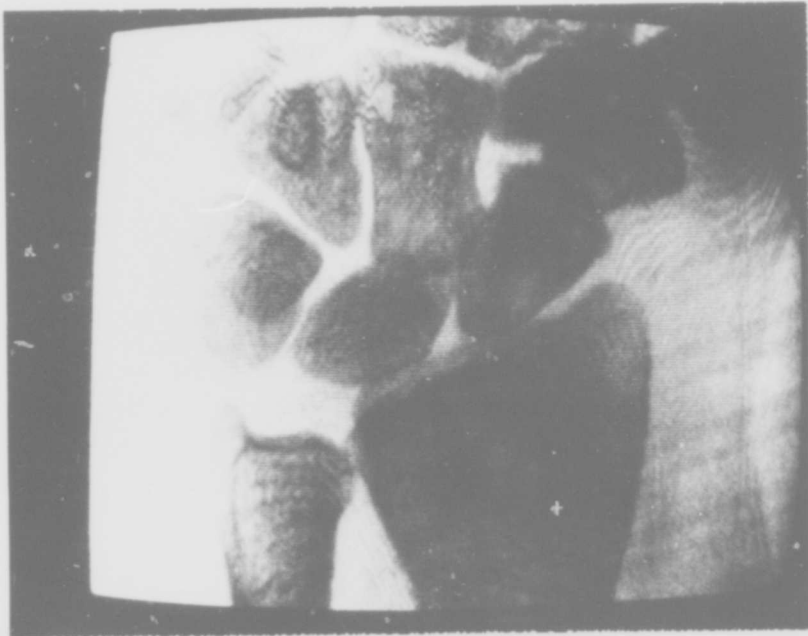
Transmission via hf of x-ray positive of hand.
